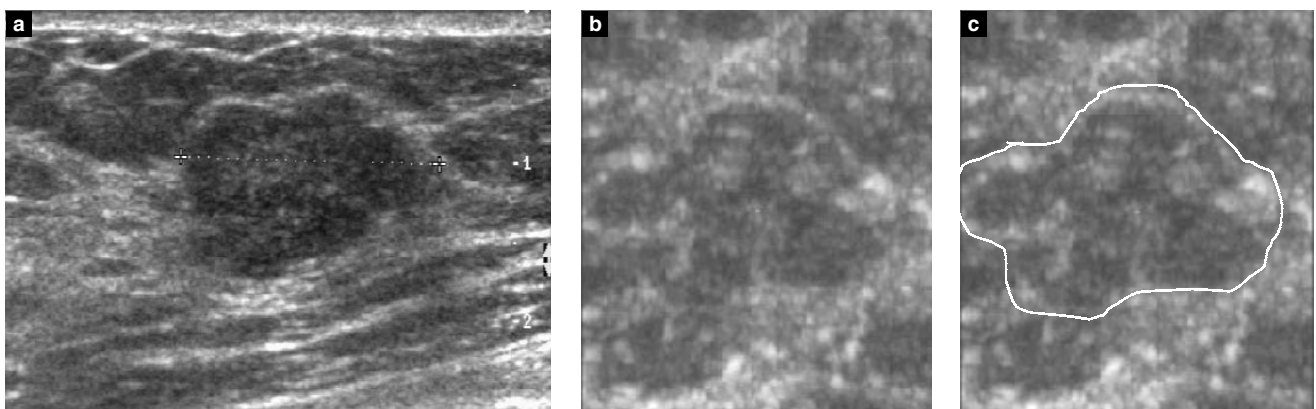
(a) Two-dimensional ultrasound image of a benign breast lesion. (b) Three-dimensional sonographic image of the same lesion in the coronal plane showing the compressive pattern. (c) The same image as (b) but showing the outline of the tumor's margin.
